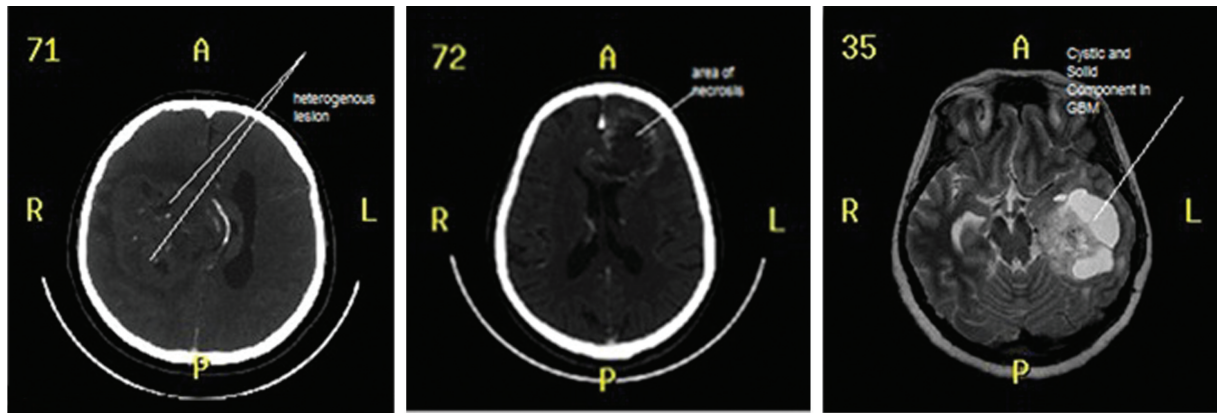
(A–C) Various preoperative glioblastoma images, (C) preoperative MRI showing a glioblastoma. MRI, magnetic resonance imaging.
